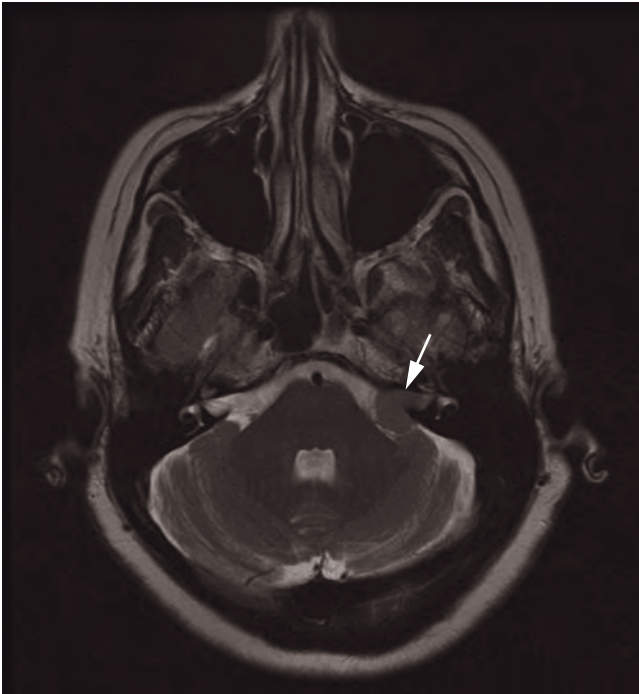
Vestibular schwannoma (MRI T2W).
